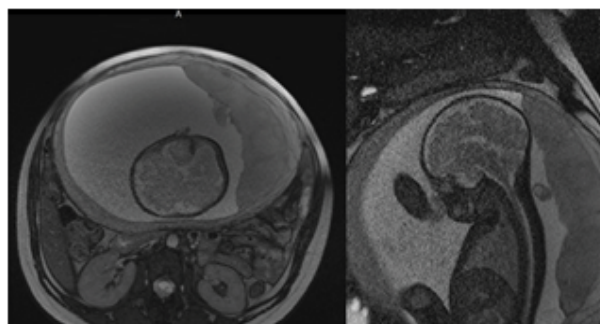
MRI showed cisterna magna was mildly obliterated, without Chiari II malformation. Falx and interhemispheric fissure were seen in the midline.
